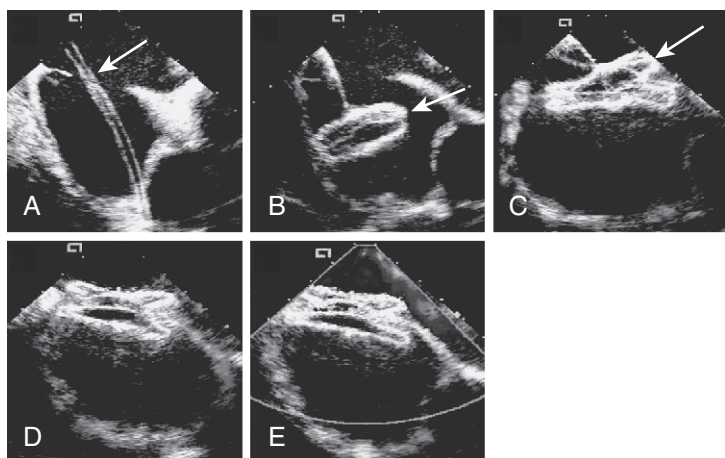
Intracardiac echocardiographic images of the patient in Figure 20-2, showing device delivery and deployment. A, Delivery sheath (arrow) across the defect into the left upper pulmonary vein. B, The left atrial disc (arrow) deployed in the left atrium. C, The right atrial disc (arrow) deployed in the right atrium. D, The device released, demonstrating good position. E, Color Doppler demonstrating no residual shunt and patent superior vena cava.
